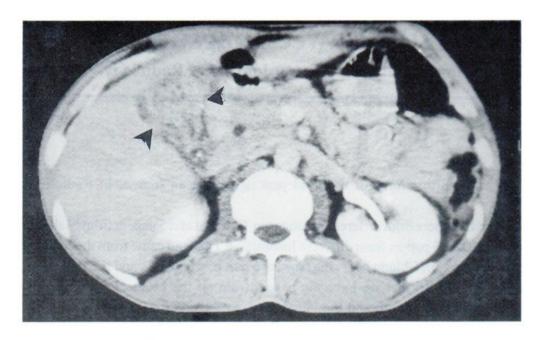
Axial CT scan showed soft tissue mass (arrow heads) at the gallbladder fossa having multiple small areas of fat density.
